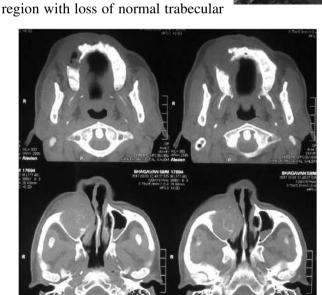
Computed Tomography - Axial Slice
